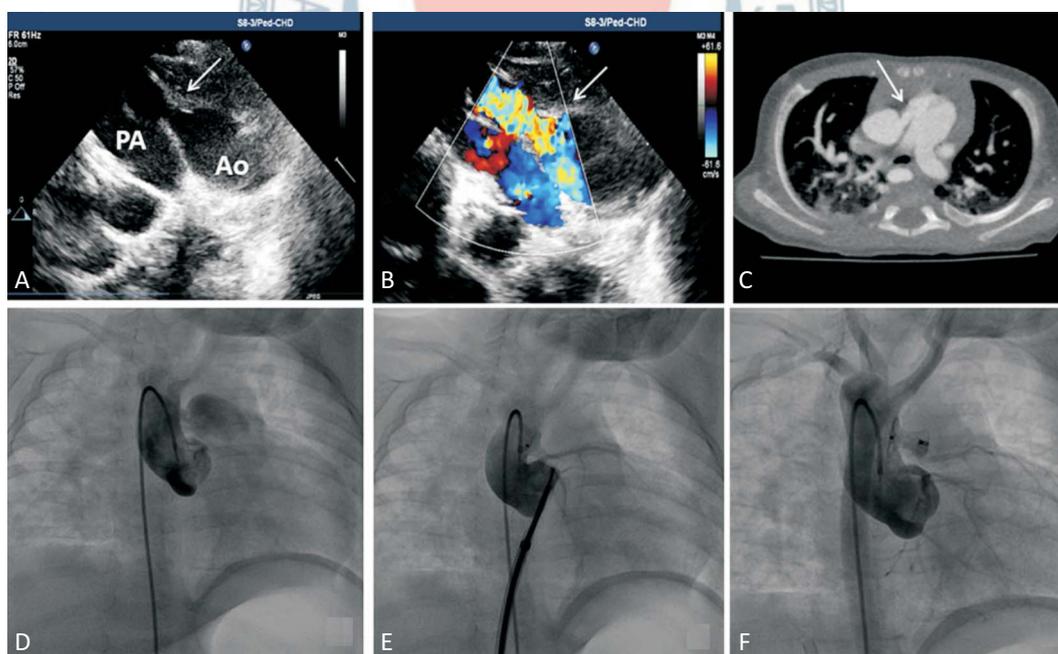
(A) Echocardiographic examination demonstrated a 3.5-4 mm wide defect between the ascending aorta and the main pulmonary artery (white arrow). (B) Color Doppler shows defect between the ascending aorta and the main pulmonary artery (white arrow). (C) Computed tomography revealed a tubular shaped APW with well-formed inferior and superior rims (white arrow). (D) Angiography shows a 4.1 mm APW at the narrowest point with a 7 mm longitudinal length. (E) Control angiogram was performed before the device was completely released. (F) Angiogram after the device was completely released. Ao, aorta; APW, aortopulmonary window; PA, pulmonary artery.
